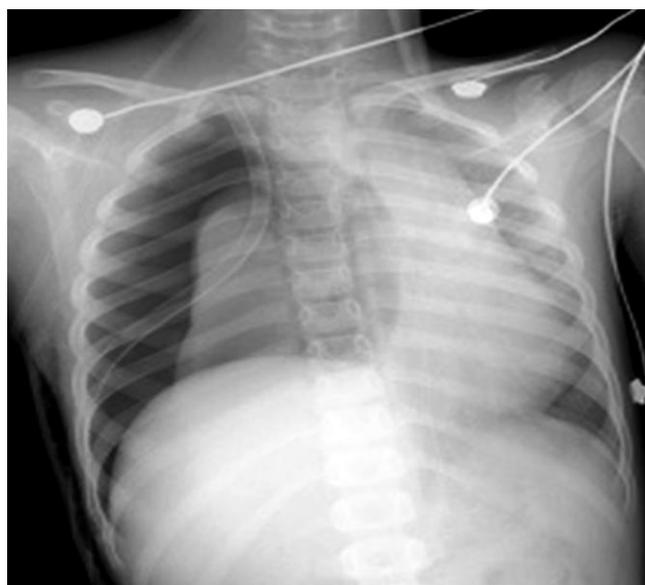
Chest x-ray revealing non-expanded lung despite the underwater-seal drainage
